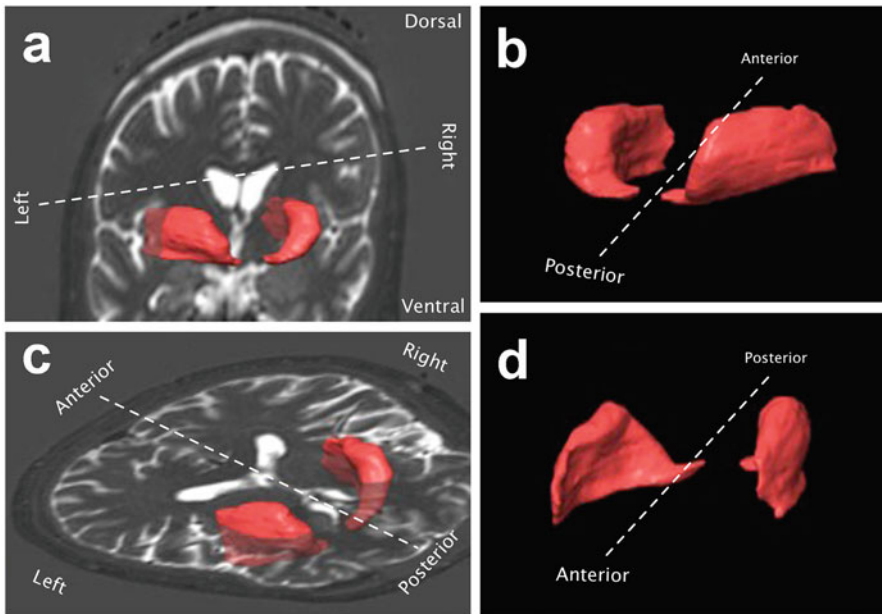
3-D reconstruction of the human parkinsonian putamen based on T2 MRI. (a) Coronal view, (b) axial view, (c) posterior view, (d) anterior view. Volume of unilateral parkinsonian putamen is approximately 4000 mm³. Delivery of viral vectors by direct putaminal infusion is challenging due to somewhat conical shape of the structure along the long axis of the nucleus. This means that trajectories must be carefully chosen to permit cannula placement such that each convection-enhanced delivery-based infusion fills as much of the tissue as possible without leakage into surrounding tissues or ventricles. In our estimation, at least a third of the targeted putaminal volume must be transduced in order to achieve therapeutic levels of expression
